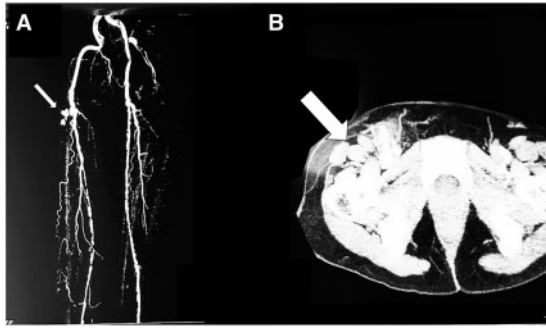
Computed tomography scan showing right femoral artery pseudo-aneurysm.
